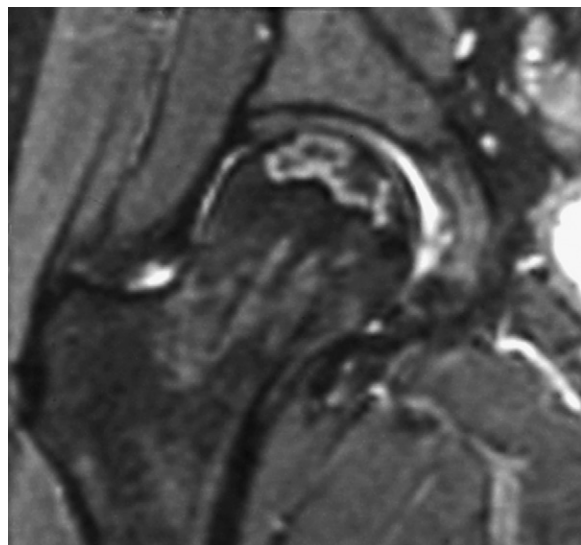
Coronal T2-weighted magnetic resonance image of the right femoral head shows the double-line sign, characteristic for osteonecrosis: low signal at periphery of the lesion and high signal band located more centrally.
